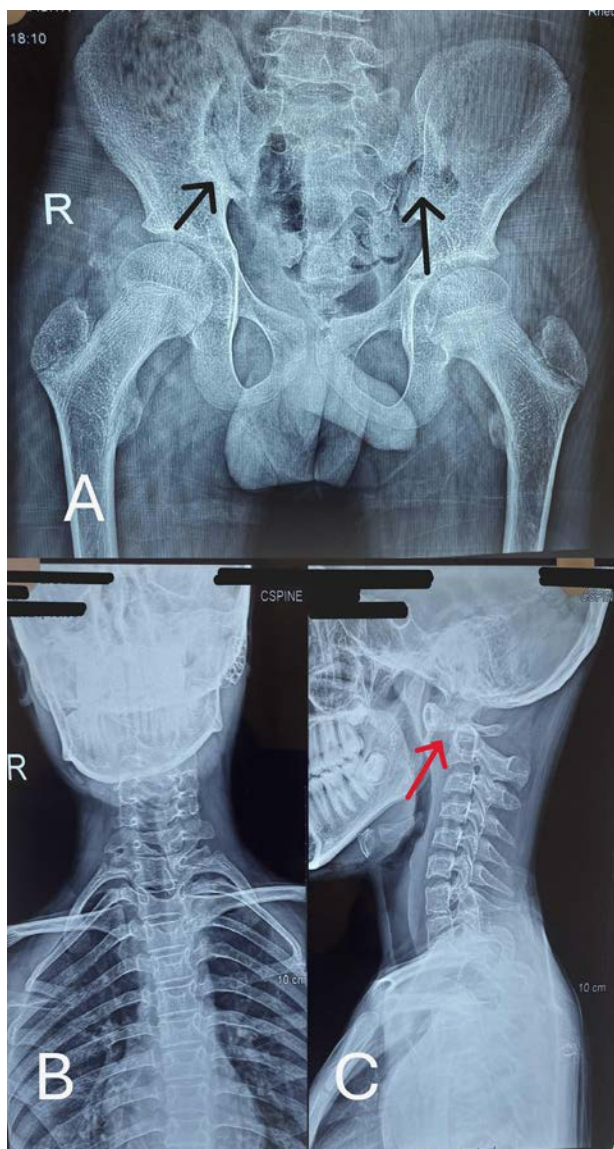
X-ray of pelvis, AP view and X-ray of neck, AP and Lateral view. (A) X-ray of pelvis AP view showing bilateral sacroiliac joint space narrowing (black arrows) suggesting bilateral sacroiliitis. (B) X-ray of neck, AP view. (C) X-ray of neck lateral view showing anterior subluxation (red arrow) of C1 (atlas) over C2 (axis).
